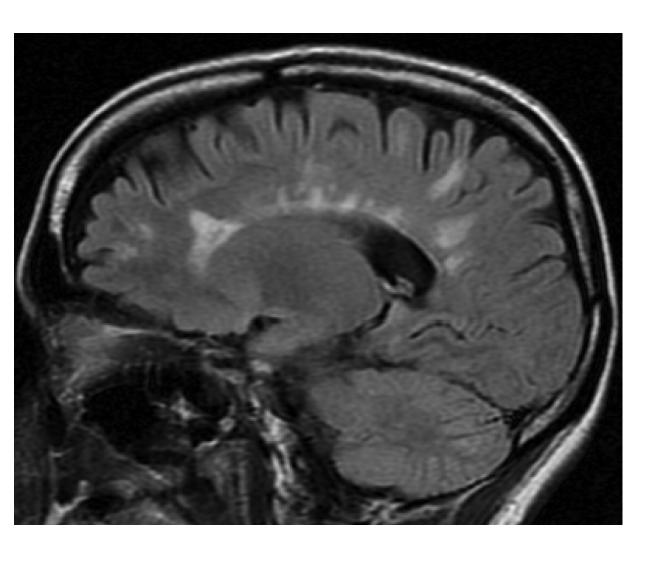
Axial and saggital FLAIR with typical ovoid demylinating lesions. Note periventricular and juxtacortical lesions.
